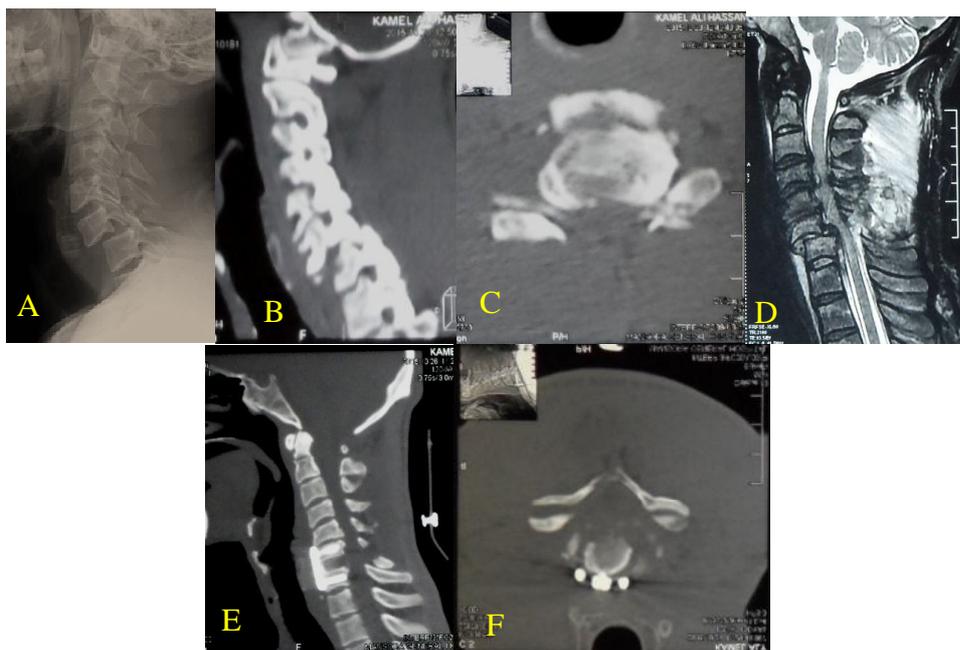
Male patient with 55 years old, with history of falling from a high, presented by quadriplegia, and sensory level at C5 (complete spinal cord injury, ASIA Grade A).(A) Pre-operative cervical X-ray,(B&C) CT scan and (D) MRI, with C6-7 anterolithesis and bilateral locked facet. (E)Post-operative sagittal CT scan and (F) axial CT scan views.
